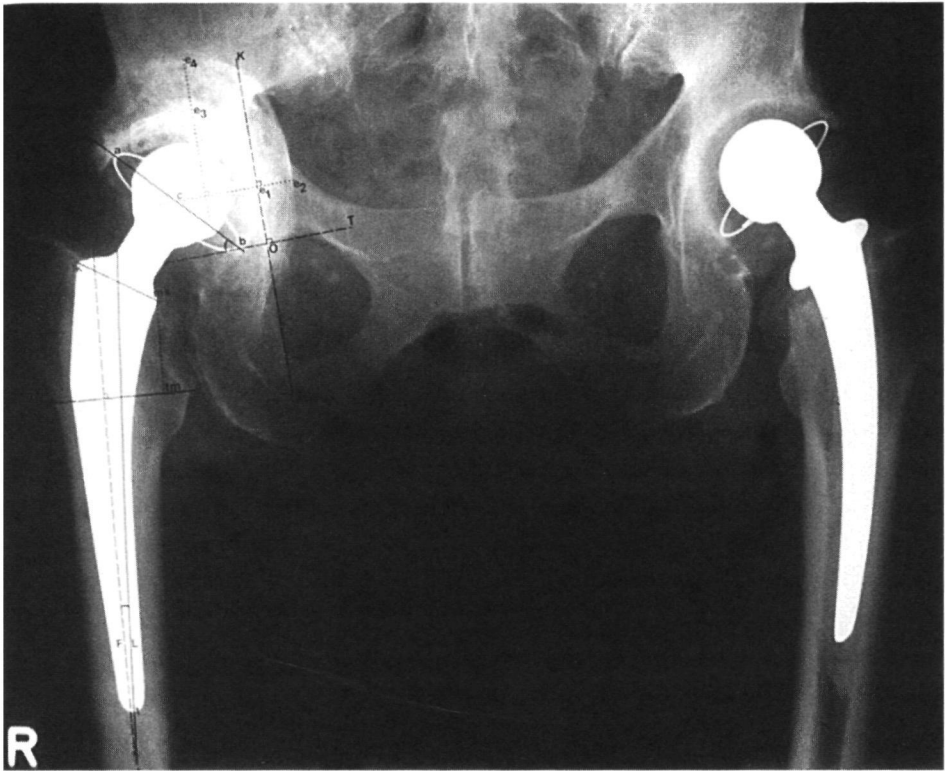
Anterior-posterior pelvis radiograph. The right acetabulum is reconstructed with morsellized bone grafts. Around the acetabulum a coordinate system is shown allowing migration measurements. Line K (Y-axis): Kohler line along medial aspect of iliac and iliac bone. Line T (X-axis): perpendicular to line K and tangential to inferior aspect of teardrop. Line a-b: long axis of projected wire marker. Point c: Cup center halfway a-b. e1-e2: graft amount in medial direction. e3-e4: graft amount in superior direction.
